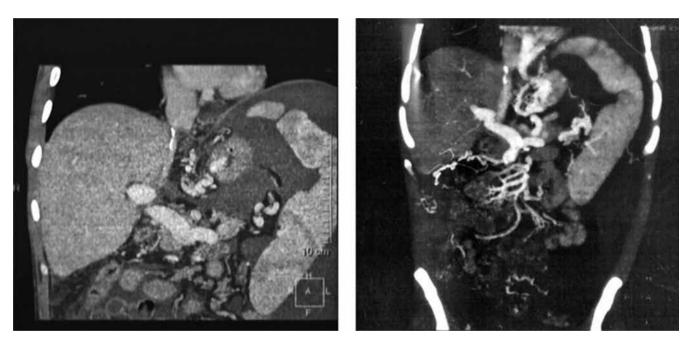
CT with bolus contrast. The liver transplant acute failure on the background of hepatic vein thrombosis. The transplantation of the right lobe of the liver from a related donor due to liver cirrhosis in the outcome of mixed HBV + HDV infection, class C, decompensation stage. MELD 36. UNOS 1B
